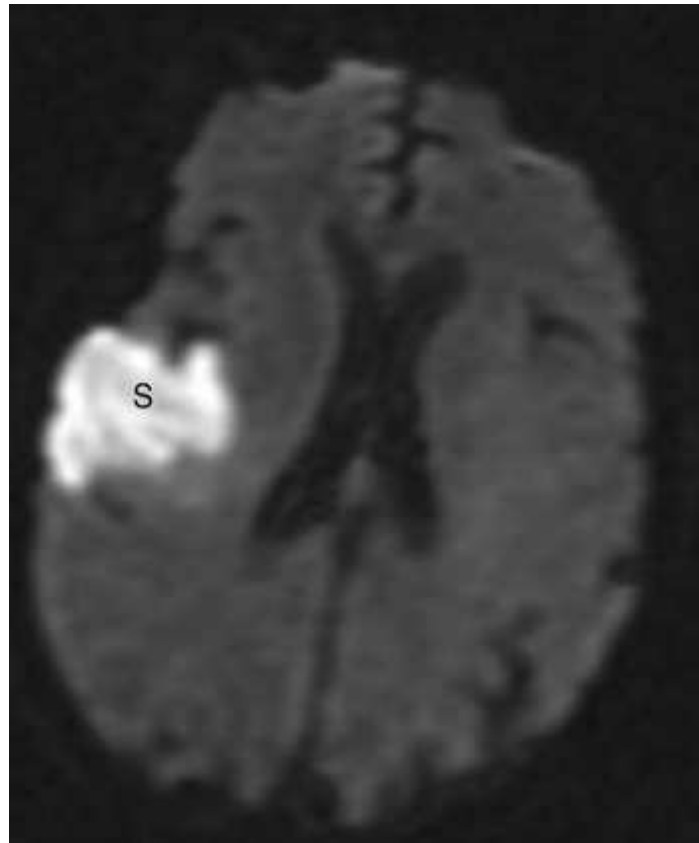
Diffusion-weighted image shows acute ischemic infarct (stroke) (S) in the territory of the right middle cerebral artery. Lack of diffusion in this area turns it bright on this heavily T2-weighted image.
